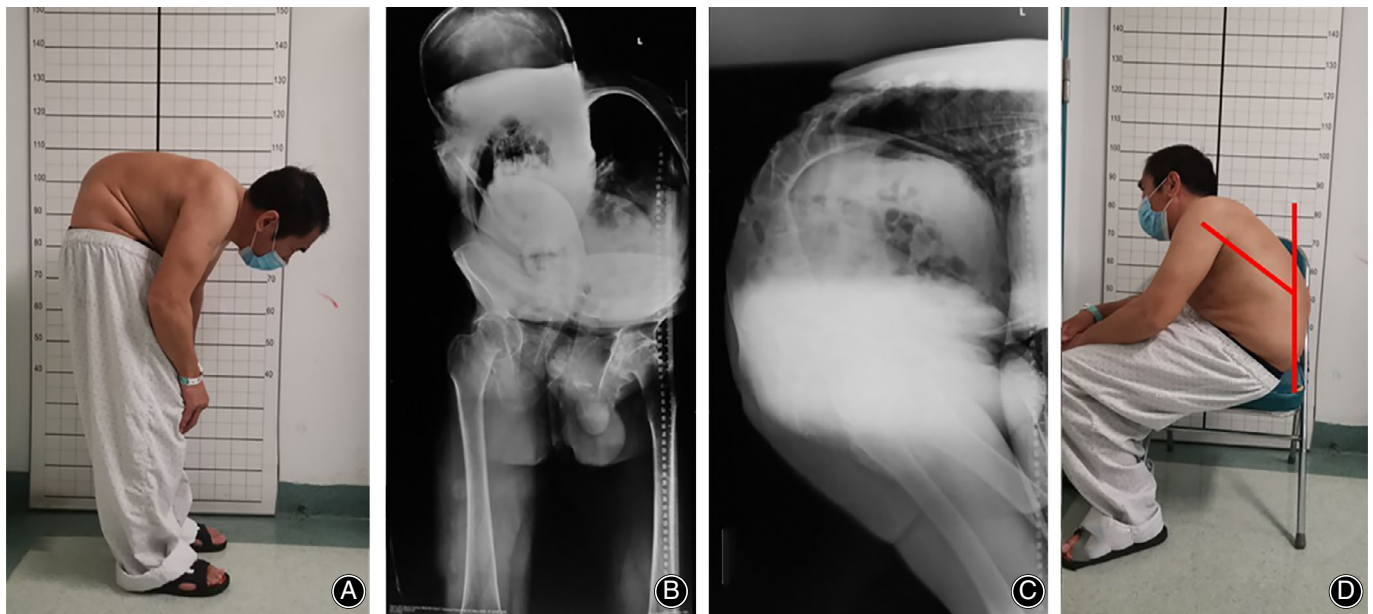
(A) Preoperative clinical photograph showed the AS patient 2 with coexisting severe thoracolumbar kyphosis and hip flexion contracture. (B, C) Anteroposterior and lateral standing X-ray revealed complete bony ankylosis in the whole spine and bilateral sacroiliac, and narrowing joint space and damage of articular surface in bilateral hip joints. (D) Photograph of the patient sitting with extreme hip flexion. The correction angle should be smaller than the angle between the line drawn from L₂ to the shoulder and the vertical axis.
